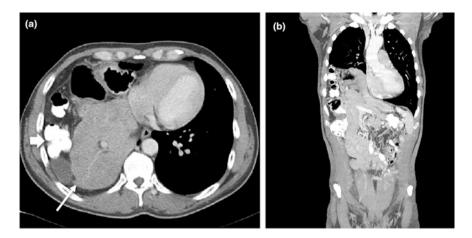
Axial (a) and coronal (b) CT images from a patient with right sided diaphragm rupture. a With herniation of liver (thin arrow) and colon (thick arrow) into the thorax. The liver (thin arrow) has compressed and displaced the lung in the right costophrenic space and now appears to lie on the posterior ribs (the dependent viscera sign) b The right hemidiaphragm appears to extend more cranial than the left on the coronal CT due to the tear of the right diaphragm
